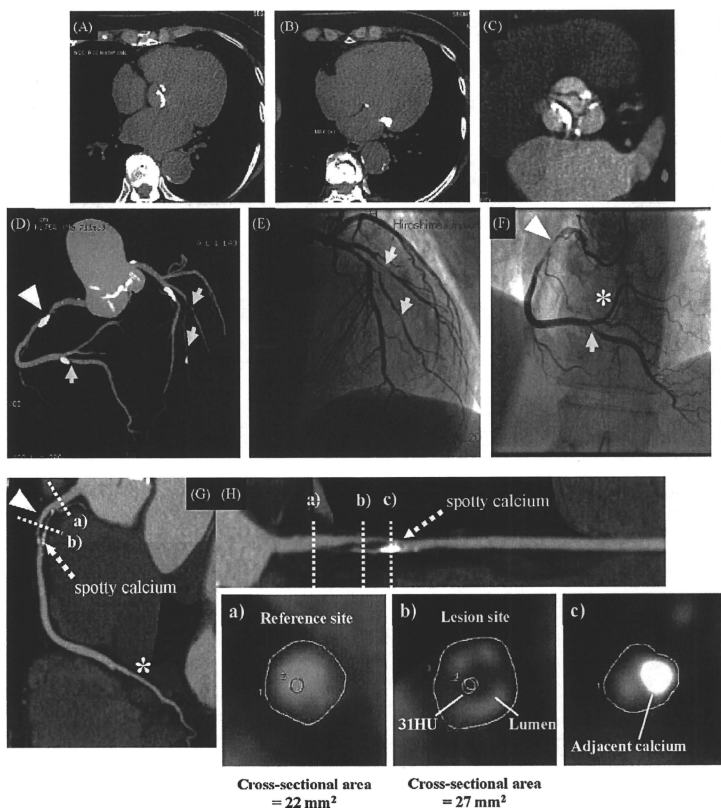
A representative case with the combined presence of aortic valve calcification (AVC) (panel A) and mitral annular calcification (MAC) (panel B) presenting mixed coronary atherosclerotic plaque (MCAP) with vulnerable characteristics. The double oblique transversal image shows calcified lesions at all leaflets (panel C). The maximum intensity projection image and invasive coronary angiography shows a severe stenosis of the proximal portion of the right coronary artery (arrowhead) and multiple obstructive lesions (panels D–F, yellow arrow). The multiplanar reconstruction image of the right coronary artery shows an obstructive MCAP with positive vascular remodeling and adjacent spotty calcium (panels G and H). The remodeling index is 1.23, calculated from the cross-sectional images of the reference site (a) and the lesion site (b). The minimum CT density of the lesion site is 31 HU. Adjacent spotty calcium can be observed in the cross-sectional image (c). (For interpretation of the references to colour in this figure legend, the reader is referred to the web version of the article.)
